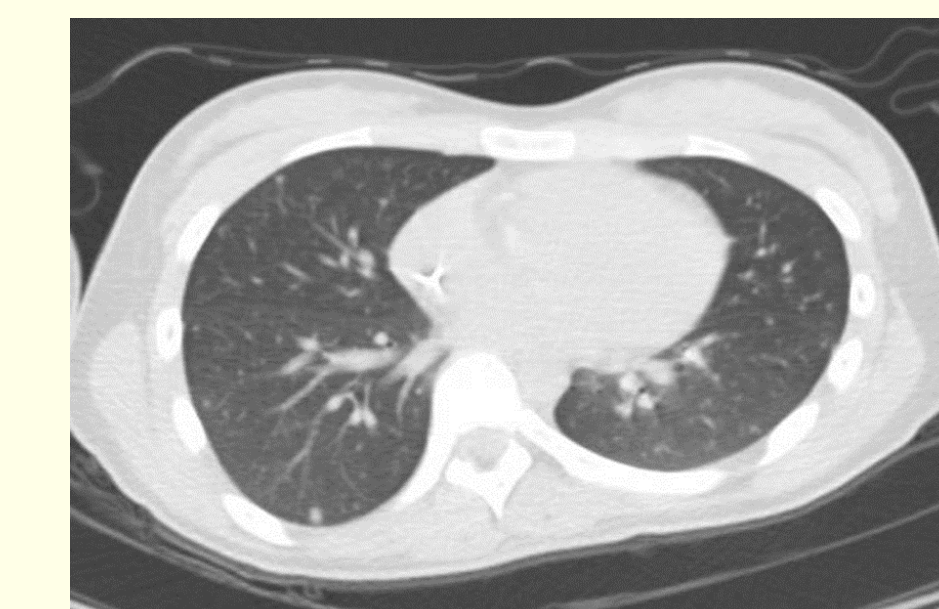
CT scan demonstrating nodular pulmonary infiltrates proven to be caused by *Trichosporon faecale*
